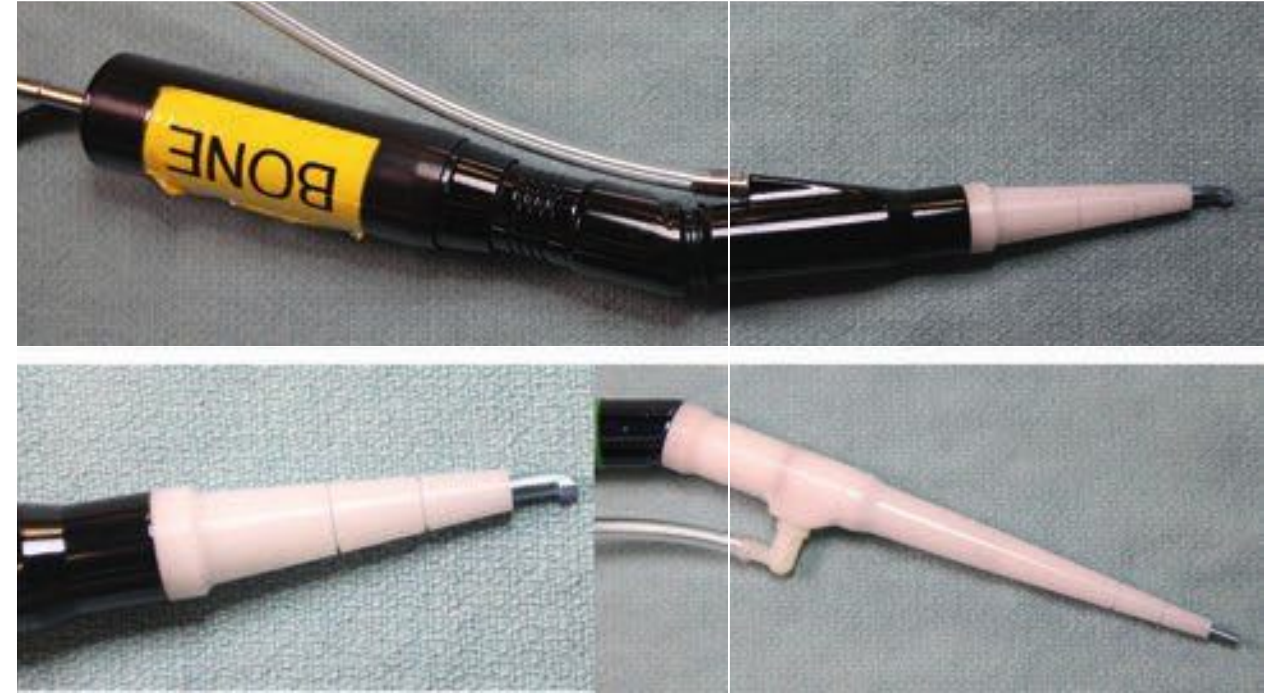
The ultrasonic bone curette tip (top panel and bottom left). A soft tissue attachment is also available (bottom right) for aspiration of soft tissue, such as brain or tumor tissue.
